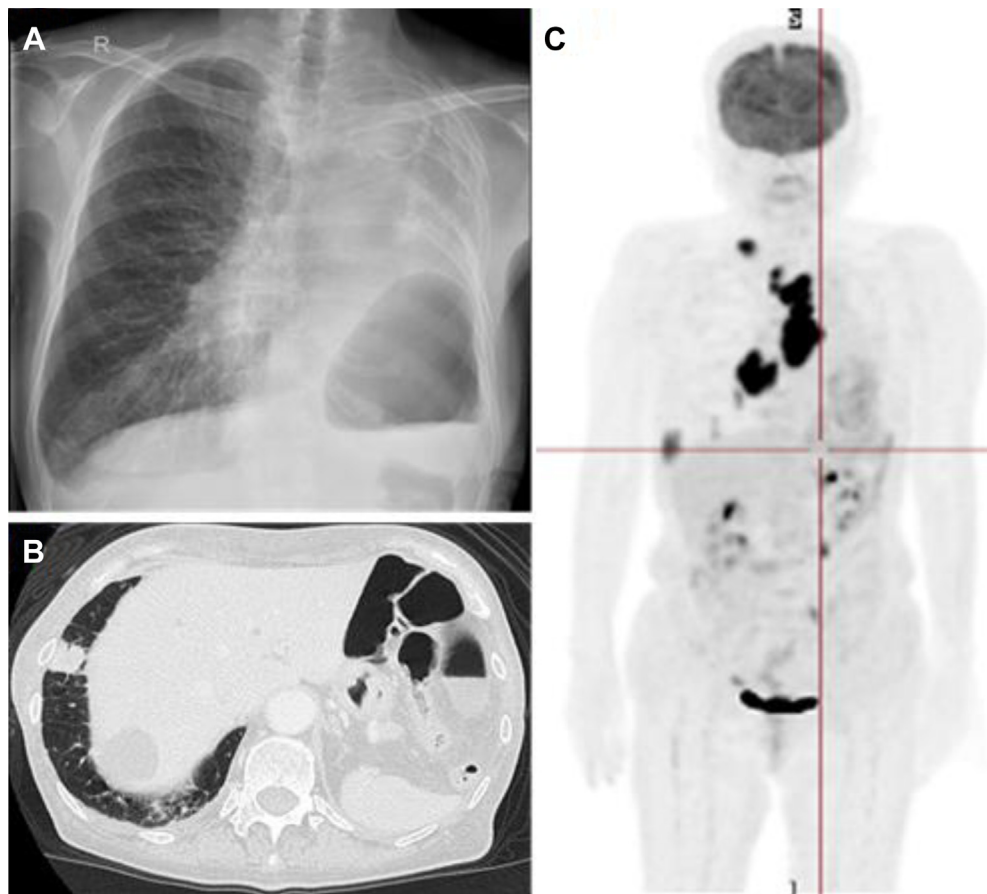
(A) Chest radiograph results after left pneumonectomy for pulmonary tuberculosis revealing a mass in the right lower lung field. (B) Primary tumor on chest computed tomography scan. (C) Primary tumor and N3 lymph node metastasis on positron emission tomography.
